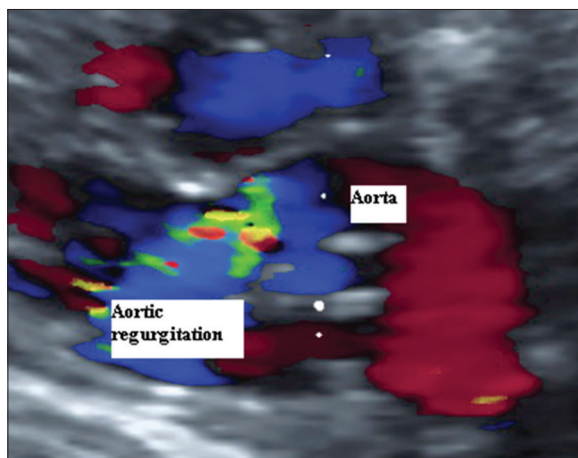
Fetal echocardiogram performed at 27 weeks of gestation demonstrates: Color Doppler across the left ventricular outflow tract shows severe aortic regurgitation
